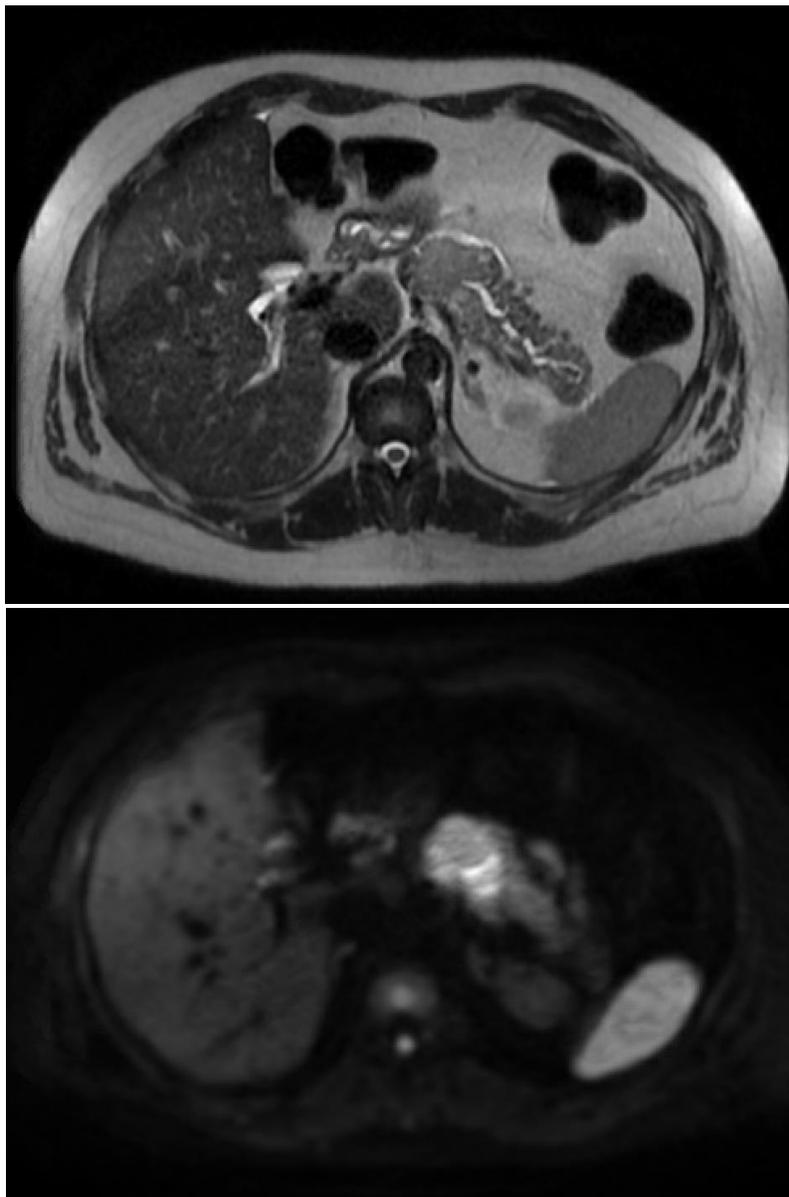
Outside MR study (A) axial T2 and (B) high b-value DWI; showed focal mass in the pancreatic body with intermediate signal intensity on T2-weighted images and diffusion restriction, with mild upstream main pancreatic ductal dilatation. Note the minimal stranding of the adjacent fat planes.
